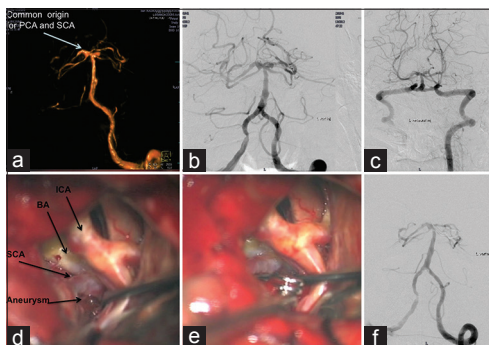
(a) CTA and (b and c) DSA of a 66-year-old female with Grade 3 SAH showing a 4.9 mm aneurysm arising from the left SCA, directed upward and posteriorly. The right PCA and SCA are seen arising from a single common trunk. The aneurysm was clipped using a temporopolar approach. (d) The aneurysm arising from the SCA, distal to its origin. (e) And the final clip placement across the aneurysm neck. (f) Postoperative angiogram shows complete occlusion of the aneurysm and flow across the patent SCA)
